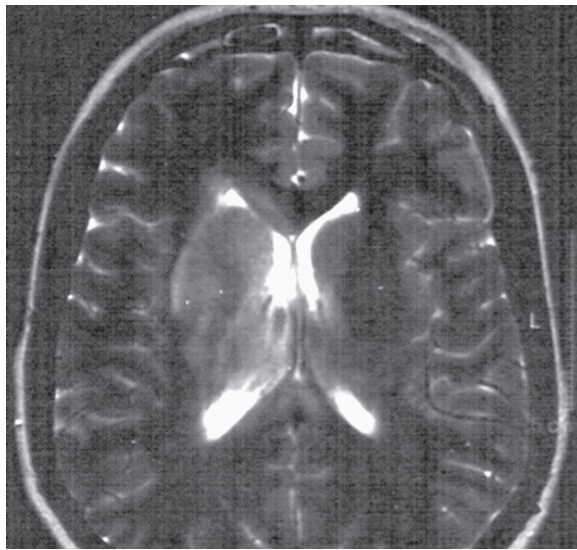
DSA, MRI + MR venography of a 24-year-old woman with CVDS thrombosis. A, B) DSA (day 1) showing no flow in the straight sinus, vein of Galen, internal cerebral veins and Basal vein of Rosenthal, cortical vein drainage was visible. C, D) T2- weighted images (day 4)- deep right thalamic and basal ganglia swelling and hyperintensity E) Lateral MR venography view (day 4) - partial superior sagittal sinus, straight sinus, complete transverse sinus thrombosis, no flow in basal vein of Rosenthal. F) Anter-posterior MR venography view - right transverse and sigmoid sinus thrombosis.
